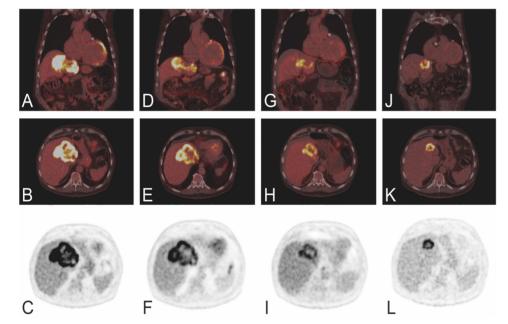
Response monitoring of liver metastases. PET/CT (A, B, D, E, G, H, J, K) and PET (C, F, I, L), before treatment (A-C), one week into treatment (D-F), after three cycles (G-I) and after six cycles (J-L).
